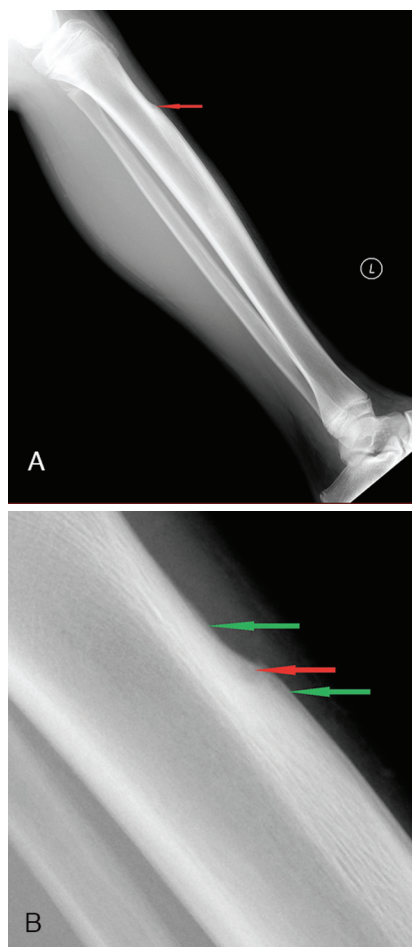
A. Lateral radiograph of the left tibia and fibula showing a lucent lesion (arrow) of the anterior tibia with subtle adjacent sclerosis and smooth periosteal reaction. B. Magnified lateral radiograph of the left tibia and fibula showing a lucent lesion (red arrow) of the anterior tibia with subtle adjacent sclerosis and smooth periosteal reaction (green arrows).
